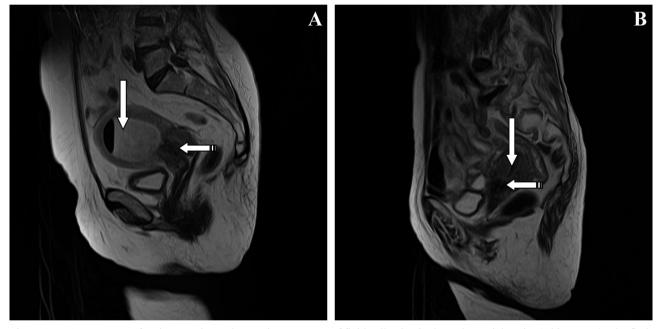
A: MRI scan of patient number 5 shows a large amount of fluid collection in the endometrial cavity (white arrow). The findings are consistent with cervical carcinoma (interrupted arrow). B: MRI scan of patient number 7 shows little fluid collection in the endometrial cavity (white arrow). The findings are consistent with endometrial carcinoma (interrupted arrow).
